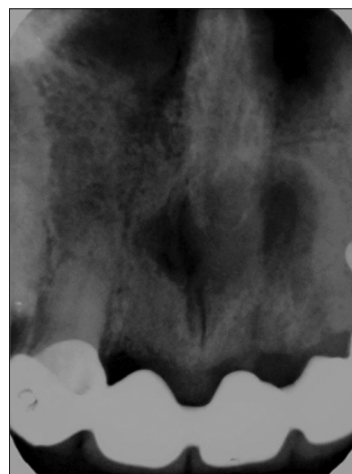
Intraoral periapical radiograph taken at 4-month follow-up showing bone fill at the alveolar defect
